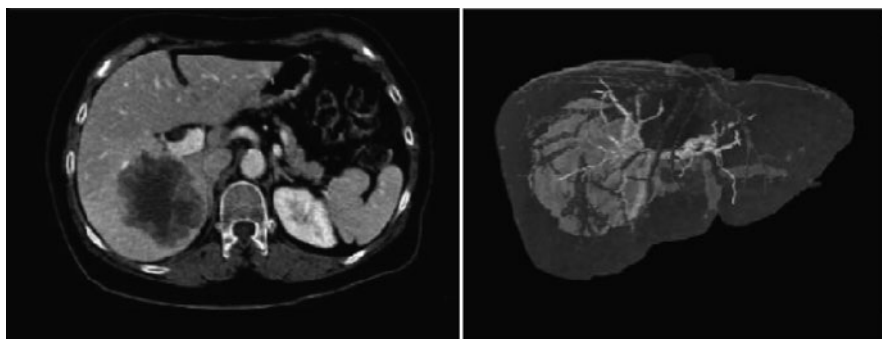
Locating a tumour in a 3D model and an equivalent CT scan (Jurgaitis et al. 2008)
